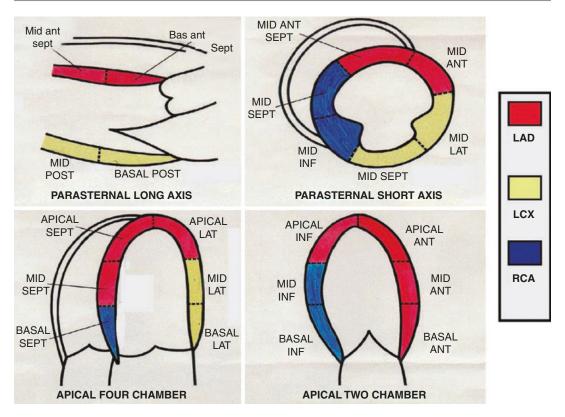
The segmental division of the left ventricle as recommended by the American Society of Echocardiography
